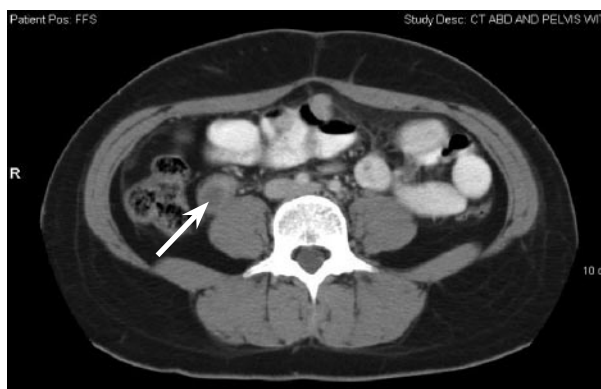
Abdominal computed tomography scan of patient 1 demonstrating resolution of retroperitoneal hematoma and organized ovarian vein thrombus (arrow).
